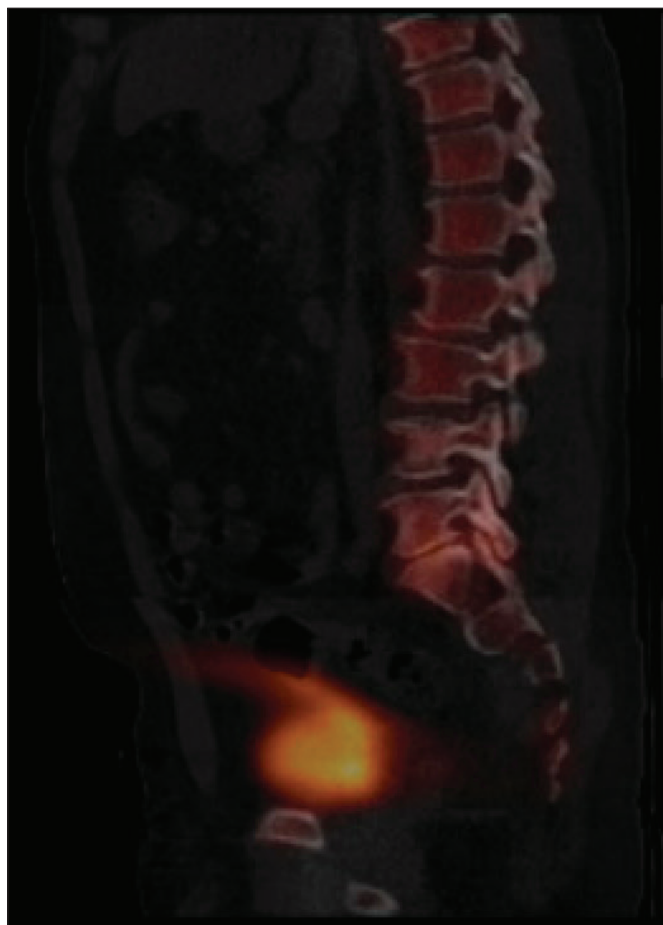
51-years-old, Male with a history of T12-L1 Laminectomy. SPECT CT was performed and demonstrated L5-S1 disc & facet joint uptake. He ended up receiving an L5-S1 TLIF. Pain at baseline before most recent surgery was a 7, at 3 months it was a 0, and at 6 months it was a 4.
